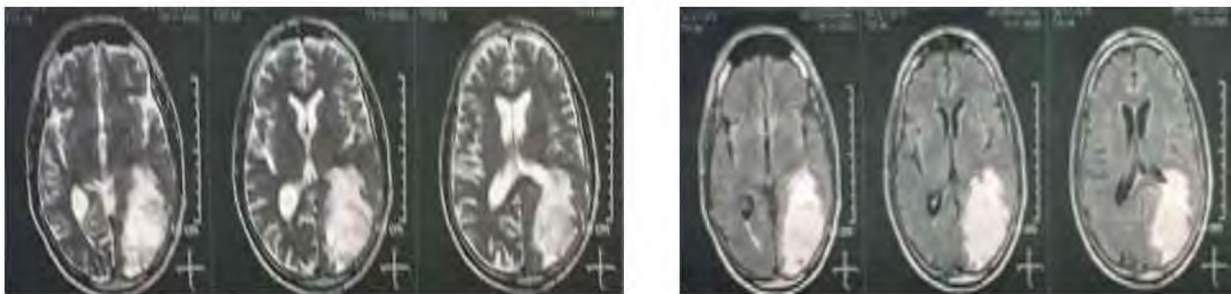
Case (1) Preoperative MRI brain showing left occipital metastasis.
